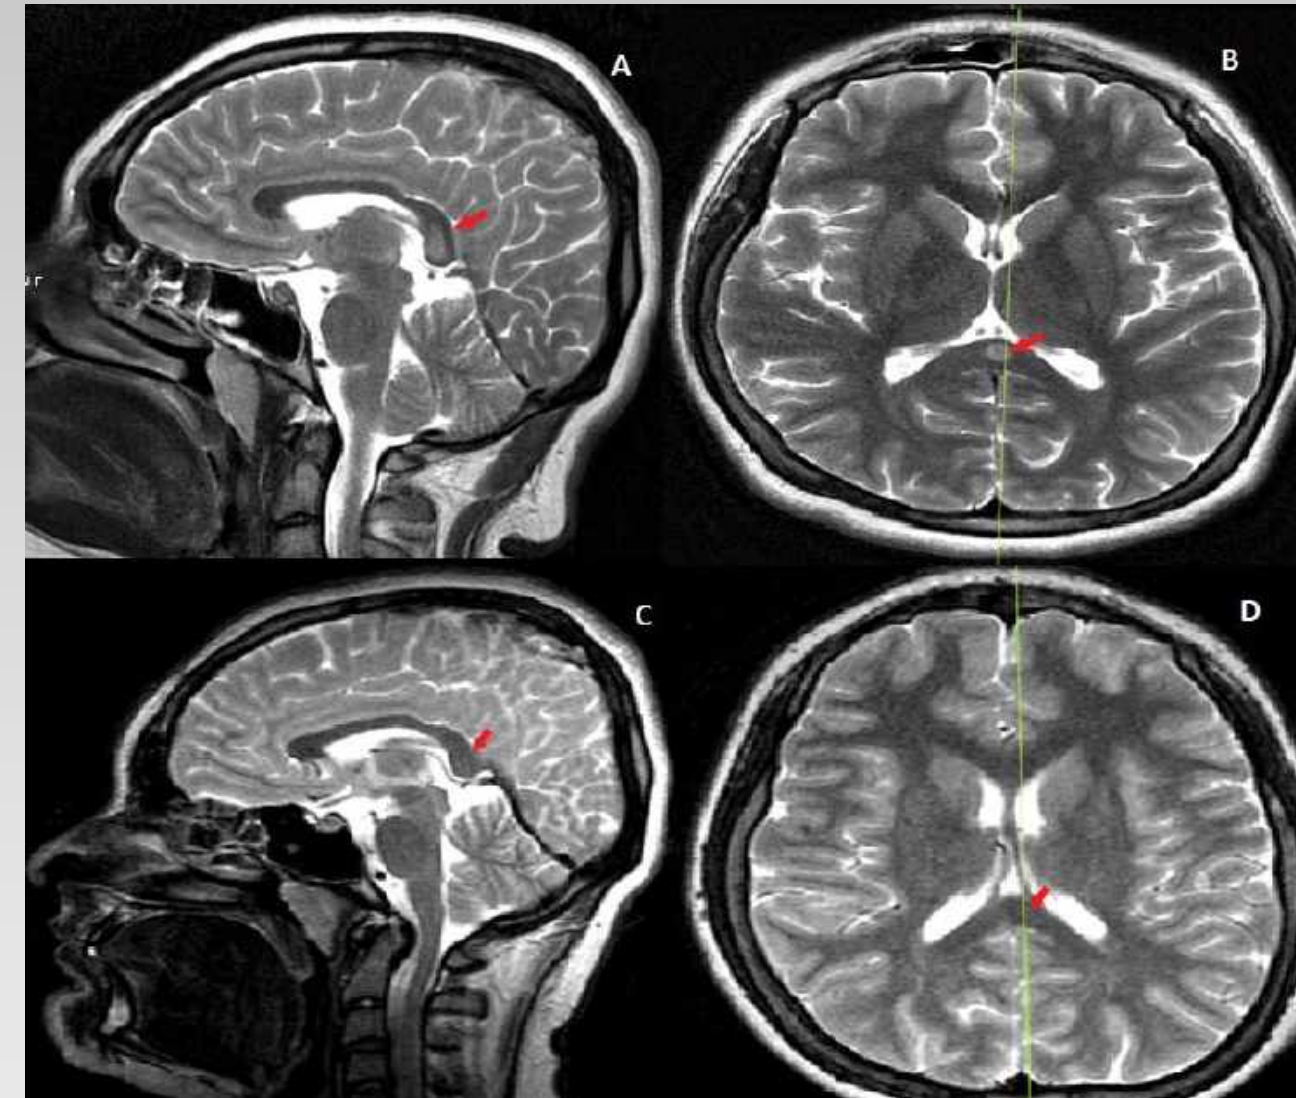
Brain magnetic resonance imaging of patient. T2-weighted sagittal (A), axial (B) images of patient show hyperintensity and restricted diffusion in the splenium of the corpus callosum. T2-weighted sagittal (C), axial (D) images of patient resolution of the lesion in the splenium of the corpus callosum.
